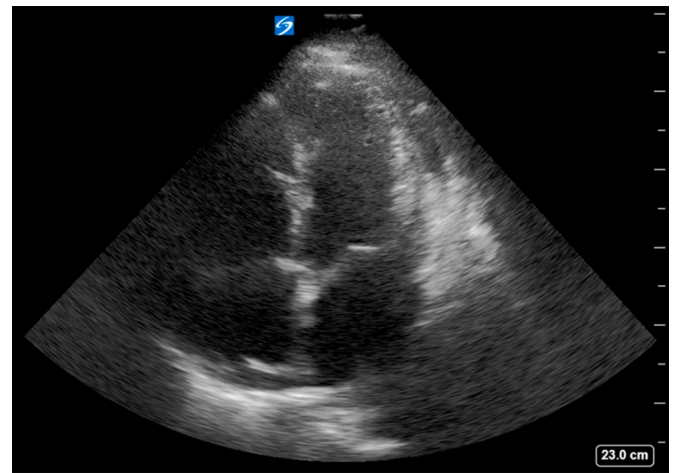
Apical 4 chamber view with aortic valve open, demonstrating just how much space the mass occupied.
